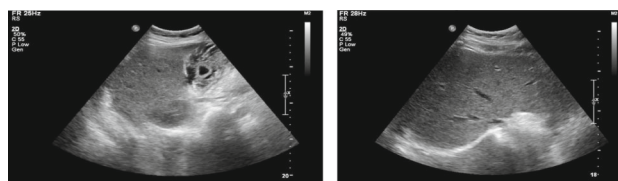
Liver ultrasonography : hepatomegaly, edematous GB
